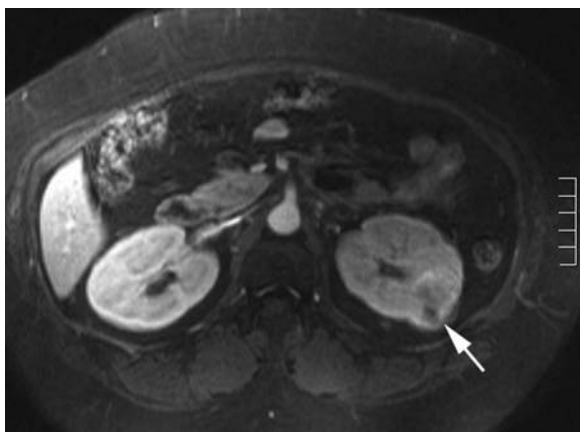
Complex left upper pole renal lesion on ultrasound exam (not shown) in a 53-year-old woman with pancreatitis. Axial contrast-enhanced fat-suppressed T1-weighted MR image shows a 2.5 cm left heterogeneously enhancing mass which proved to be a Fuhrman grade III clear cell carcinoma at surgery (*arrow*).
